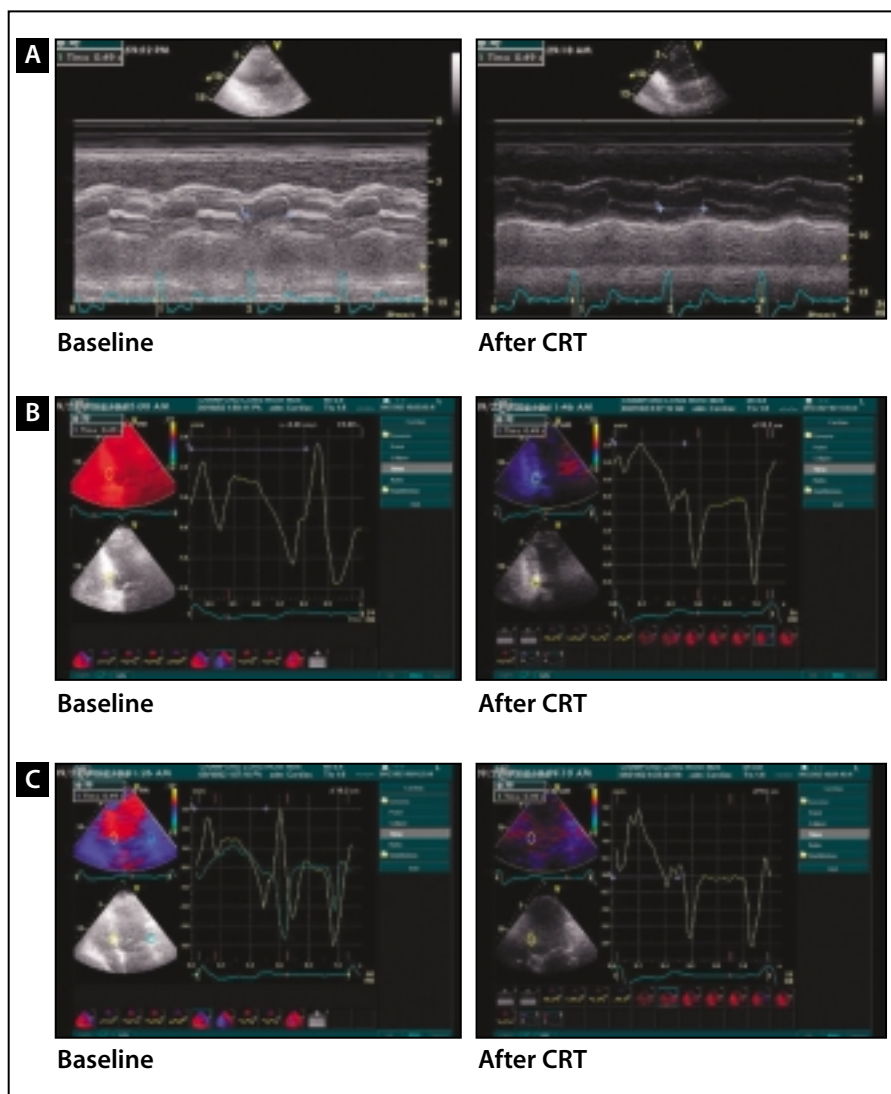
M-mode echocardiography demonstrates a delay in the opening of the aortic valve in a patient with cardiac dyssynchrony. (A) The aortic pre-ejection interval shortens after successful resynchronization, reflecting more effective left ventricular (LV) contraction during biventricular pacing. (B) Tissue Doppler imaging at one segment in the inferior septum demonstrates post-systolic contraction as an upward deflection after closing of the aortic valve. (The red line denotes closure of the aortic valve.) Resynchronization of LV contraction eliminates most of the post-systolic motion. (C) Tissue Doppler imaging allows simultaneous detection of post-systolic motion at numerous segments prior to and after resynchronization.
